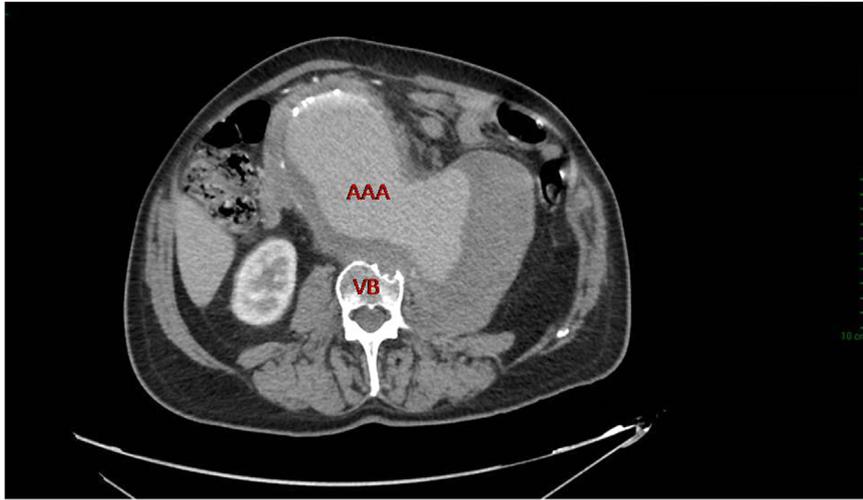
Abdominal contrast-enhanced CT scan: a giant sub-renal aortic aneurysm with evidence of rupture covered by left psoas and iliopsoas muscles and a partial erosion of vertebral body. AAA: abdominal aortic aneurysm, VB: vertebral body.
